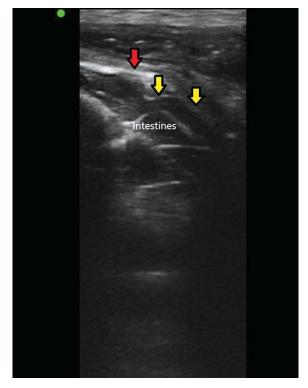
Ultrasound examination of the left inguinal hernia, bowel (red arrow) and appendix (yellow arrow) observed
